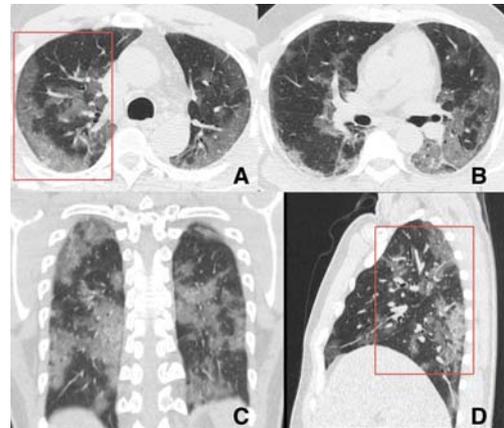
Chest CT images in axial (A, B), Coronal (C) and Sagittal (D) planes in a 37-year-old male patient with COVID-19. He presented with a 7-day history of fever and cough and two days of shortness of breath. Bilateral peripheral ground-glass opacities can be seen (red boxed) with lower zone predominance.
